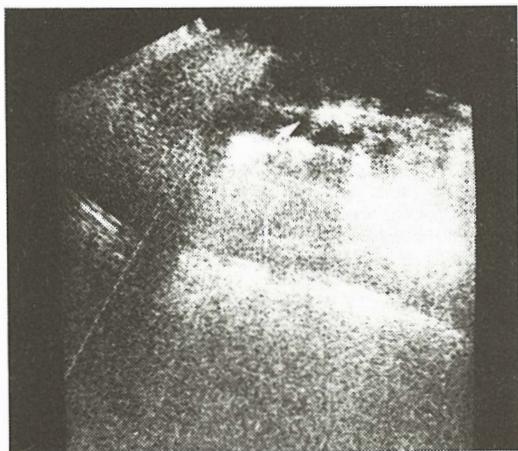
b – Real – time ultrasound: high echogeneity fibrous septa (arrow) are noted.
